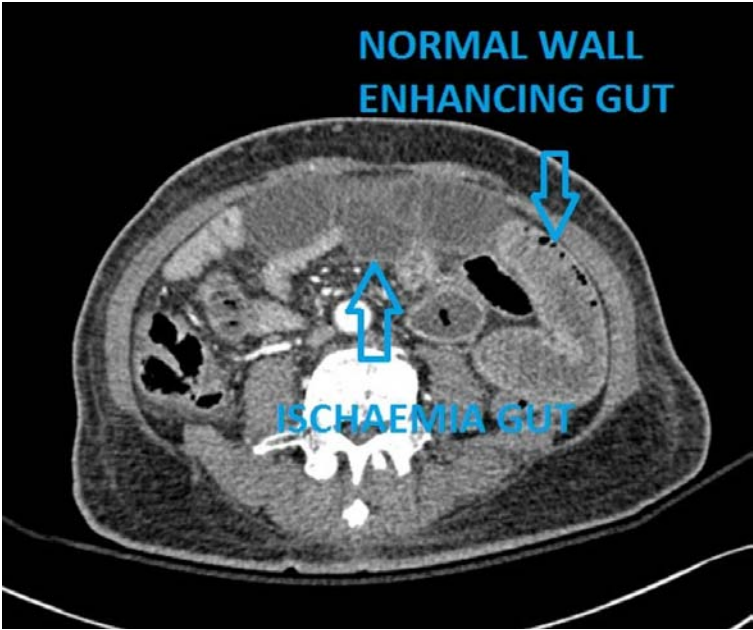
Axial Abdominal CT showing the difference between normal bowel wall enhancement and ischemic bowel wall enhancement [62]
